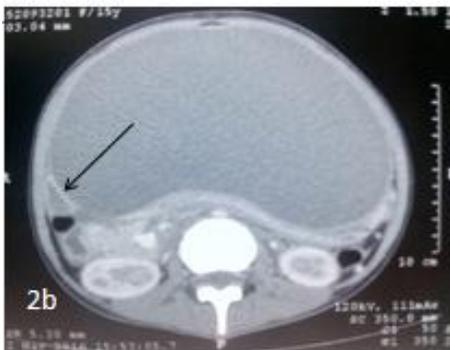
CT images at different axial planes showing a cystic hypodense lesion with occasional fine septations (black arrow).
